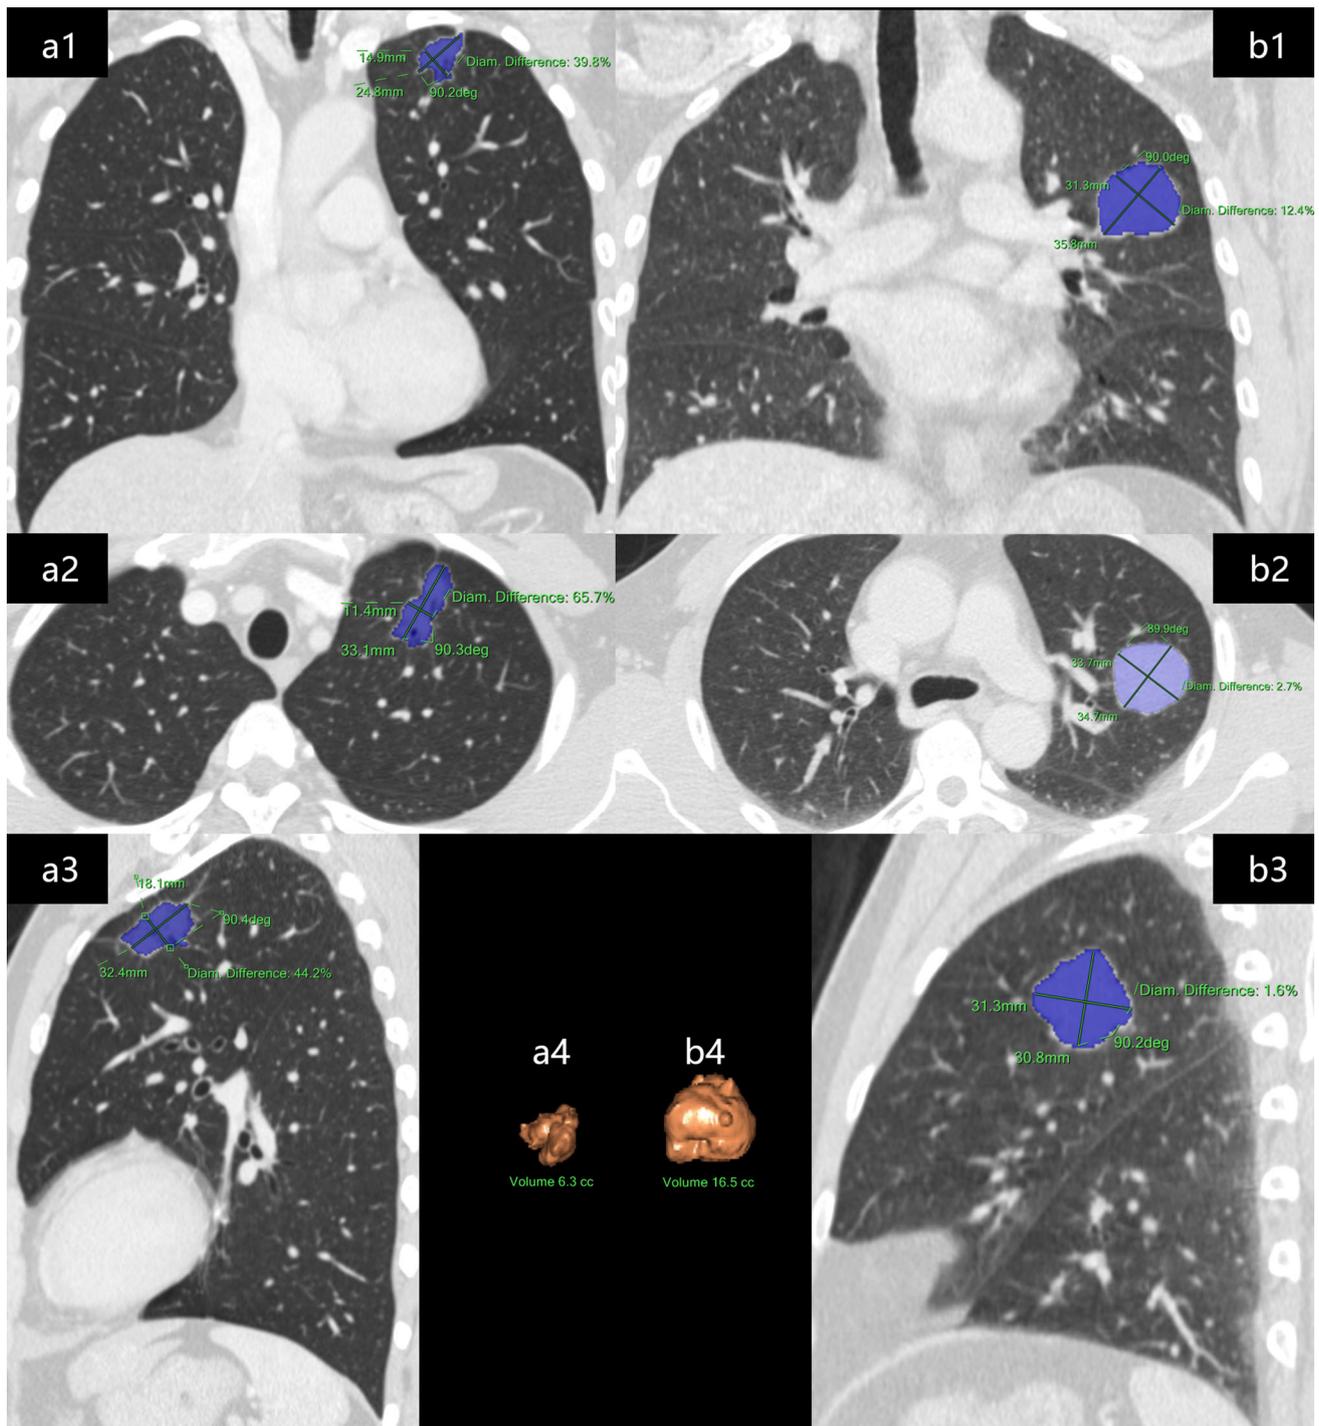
The measurement of greatest tumor diameter (GTD) on CT images. The reconstruction of tumor and its volume was automatically measured by software. The GTD of tumor a, b was
